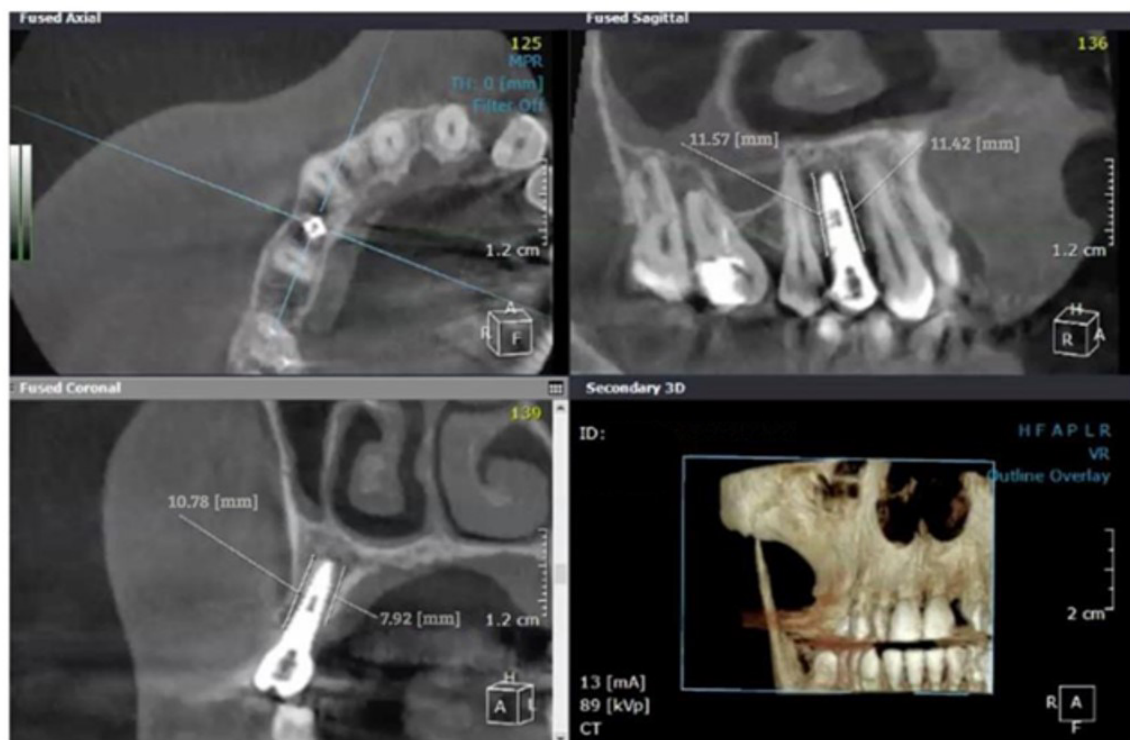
Buccal, palatal, mesial and distal CBCT measurements at 3 months.
